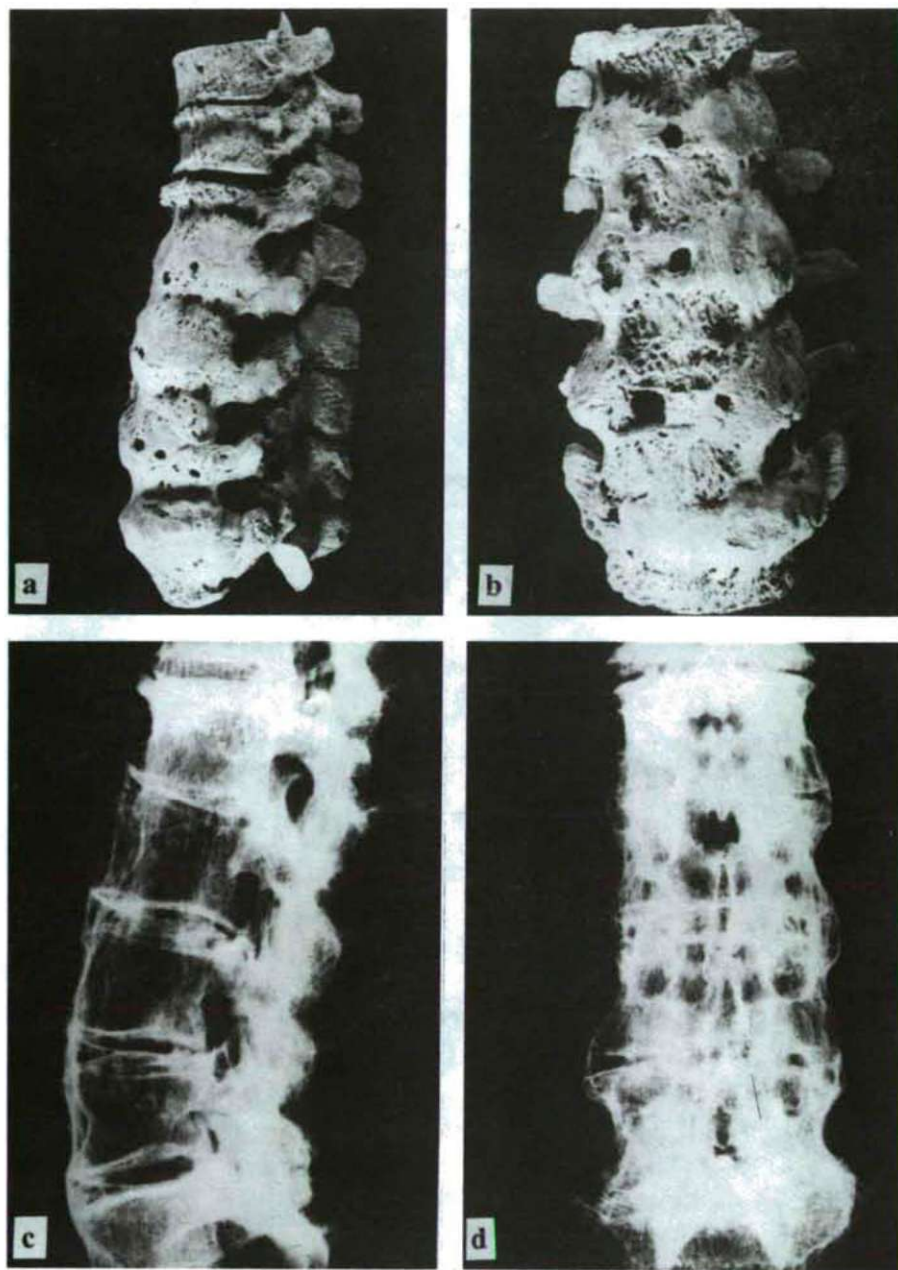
Lateral and antero-posterior macroscopic (a-b) and X-ray pictures (c-d) of the lumbar and thoracolumbar segments. Syndesmophytosis and ankylosis are must be mentioned. (Case No. 2: Grave No. 90)
